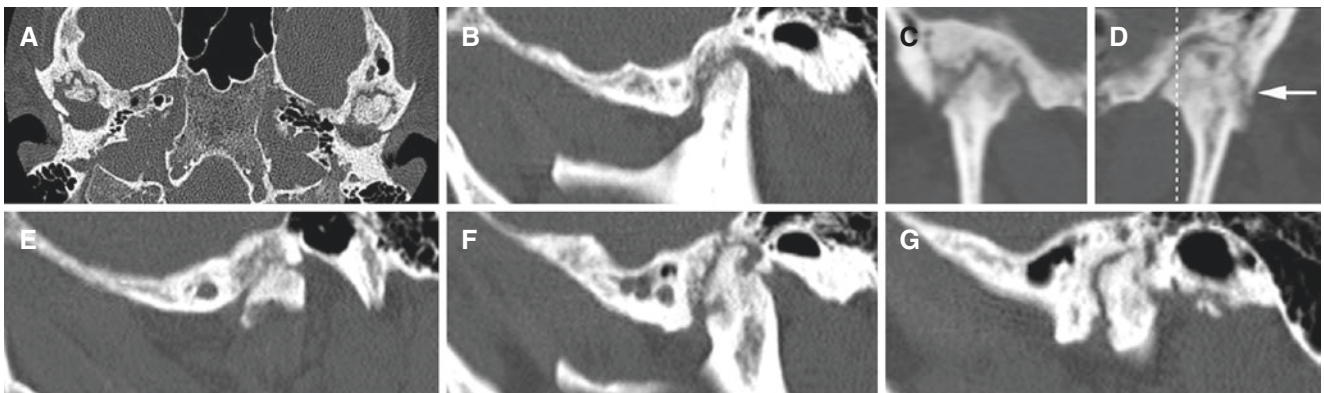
Fibro-osseous ankylosis; 53-year-old male with psoriatic arthritis. (A) Axial CT image, (B) oblique sagittal CT image of the right joint, (C) oblique coronal CT image of the right joint, and (D) oblique coronal CT image of the left joint show irregularities of joint surfaces in both joints but somewhat more evident joint space in the right joint than
